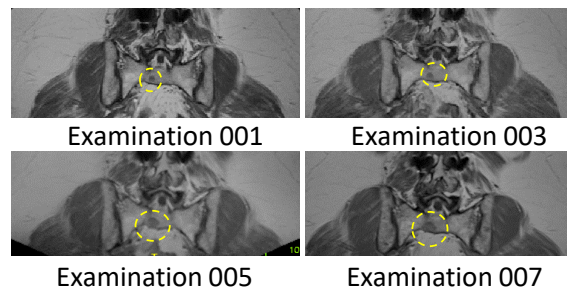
Focal bone infiltration patterns are visible in MRI scans over multiple examination time points of one patient's sacrum.
